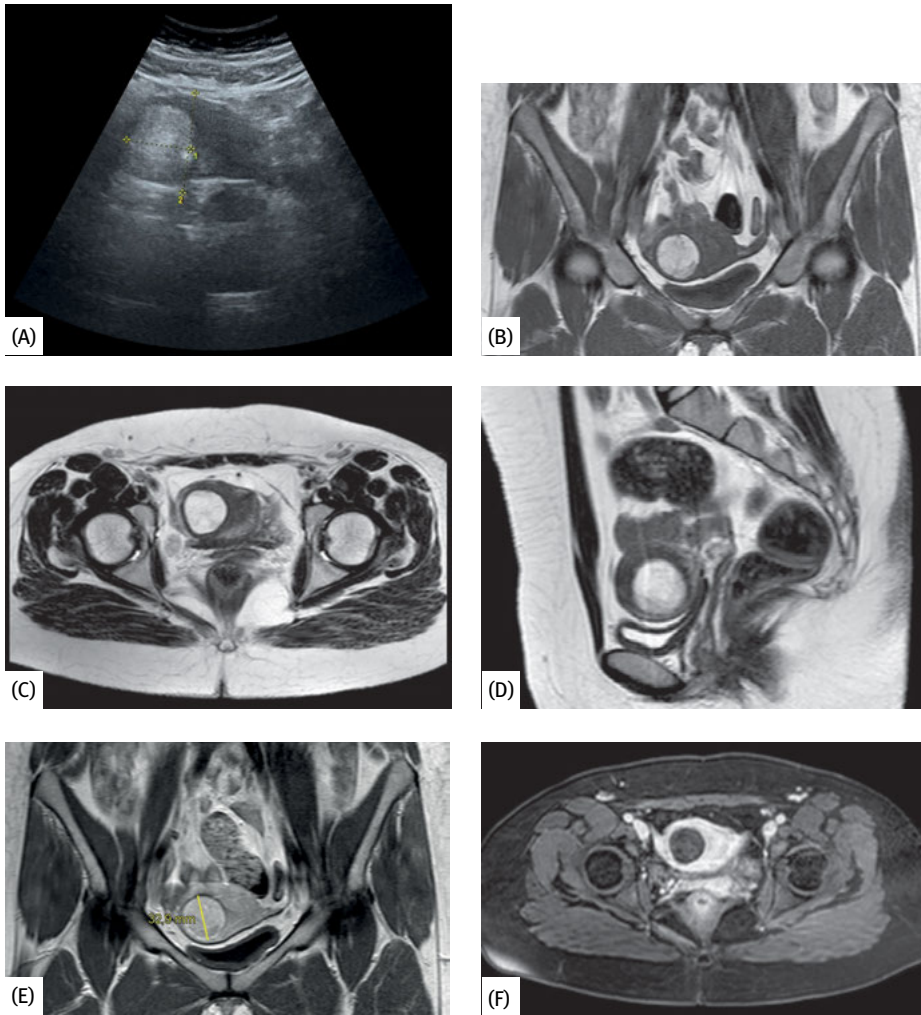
Results from imaging diagnostics performed on a 23-year-old woman with dedifferentiated uterine liposarcoma; (A) the tumor's heterogeneous hyperechoicity to normal myometrium is clearly recognizable in abdominal sonography; (B) coronal T1-weighted MRI reveals a hyperintense tumor with a clearly distinguishable (also from normal myometrium) hypointense margin as well as hypointense bands, or seams, that correspond to the dedifferentiated sections of the tumor; (C), (D) axial and sagittal T2-weighted MRI likewise reveals a tumor with high signal intensity and a hypointense border margin; (E) in T1WC, the tumor does not enhance compared to normal myometrium, the hypointense margin remains; (F) T1WC with fat suppression serves to verify the diagnosis of adipocytic tumors as the fat suppression agent causes such tumors to lose all signal intensity.
